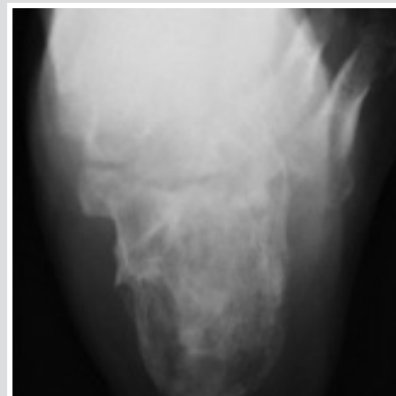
X-ray after removal of the plate.
